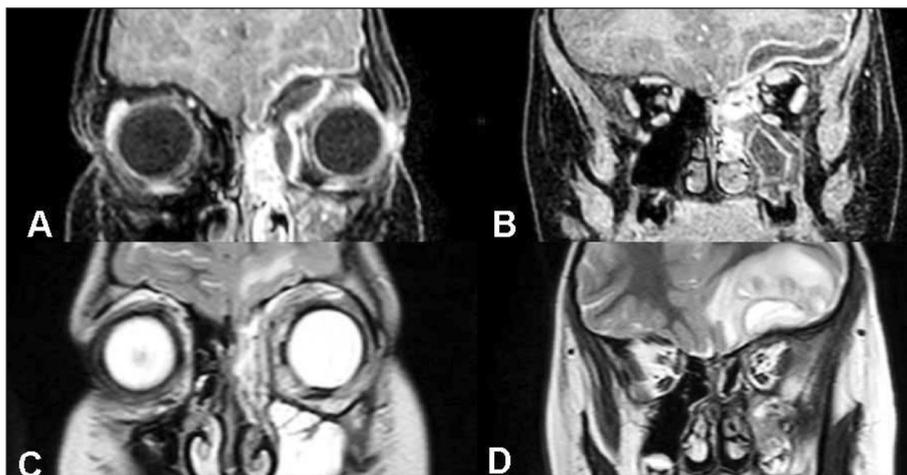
A 10-year-old male patient who developed SPOA and intracranial abscess due to left pansinusitis, A) Preoperative, medial and superomedial SPOA on contrast-enhanced T1 MRI coronal, involvement in the epidural distance, B) Preoperative, epidural abscess in contrast-enhanced T1 MRI coronal section, C) 5th day after endoscopic sinus and SPOA drainage, T2 MRI, coronal section, SPOA has regressed, D) 5th day after endoscopic sinus and SPOA drainage, T2 MRI, coronal section, epidural abscess is accompanied by intracerebral edema.
